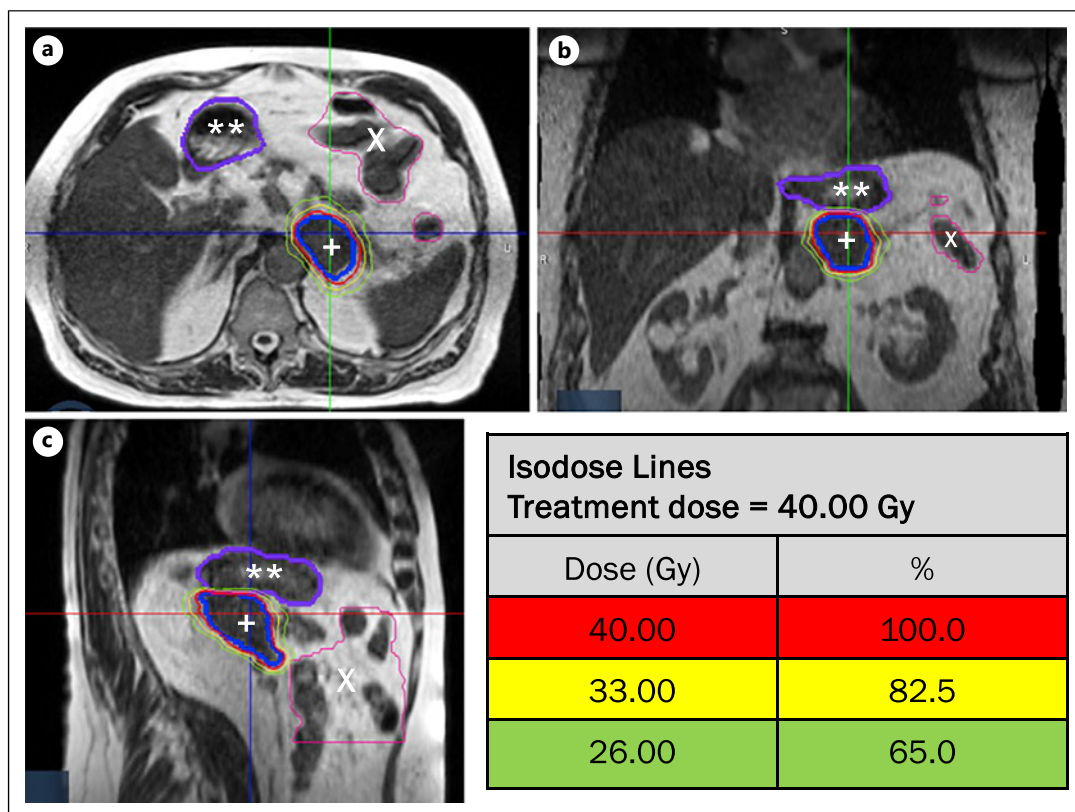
a–c MRI-guided SBRT treatment plan. Blue lines (+) represent the GTV. Purple lines and asterisks () indicate the stomach, while the magenta line (X) represents the small and large intestines.
